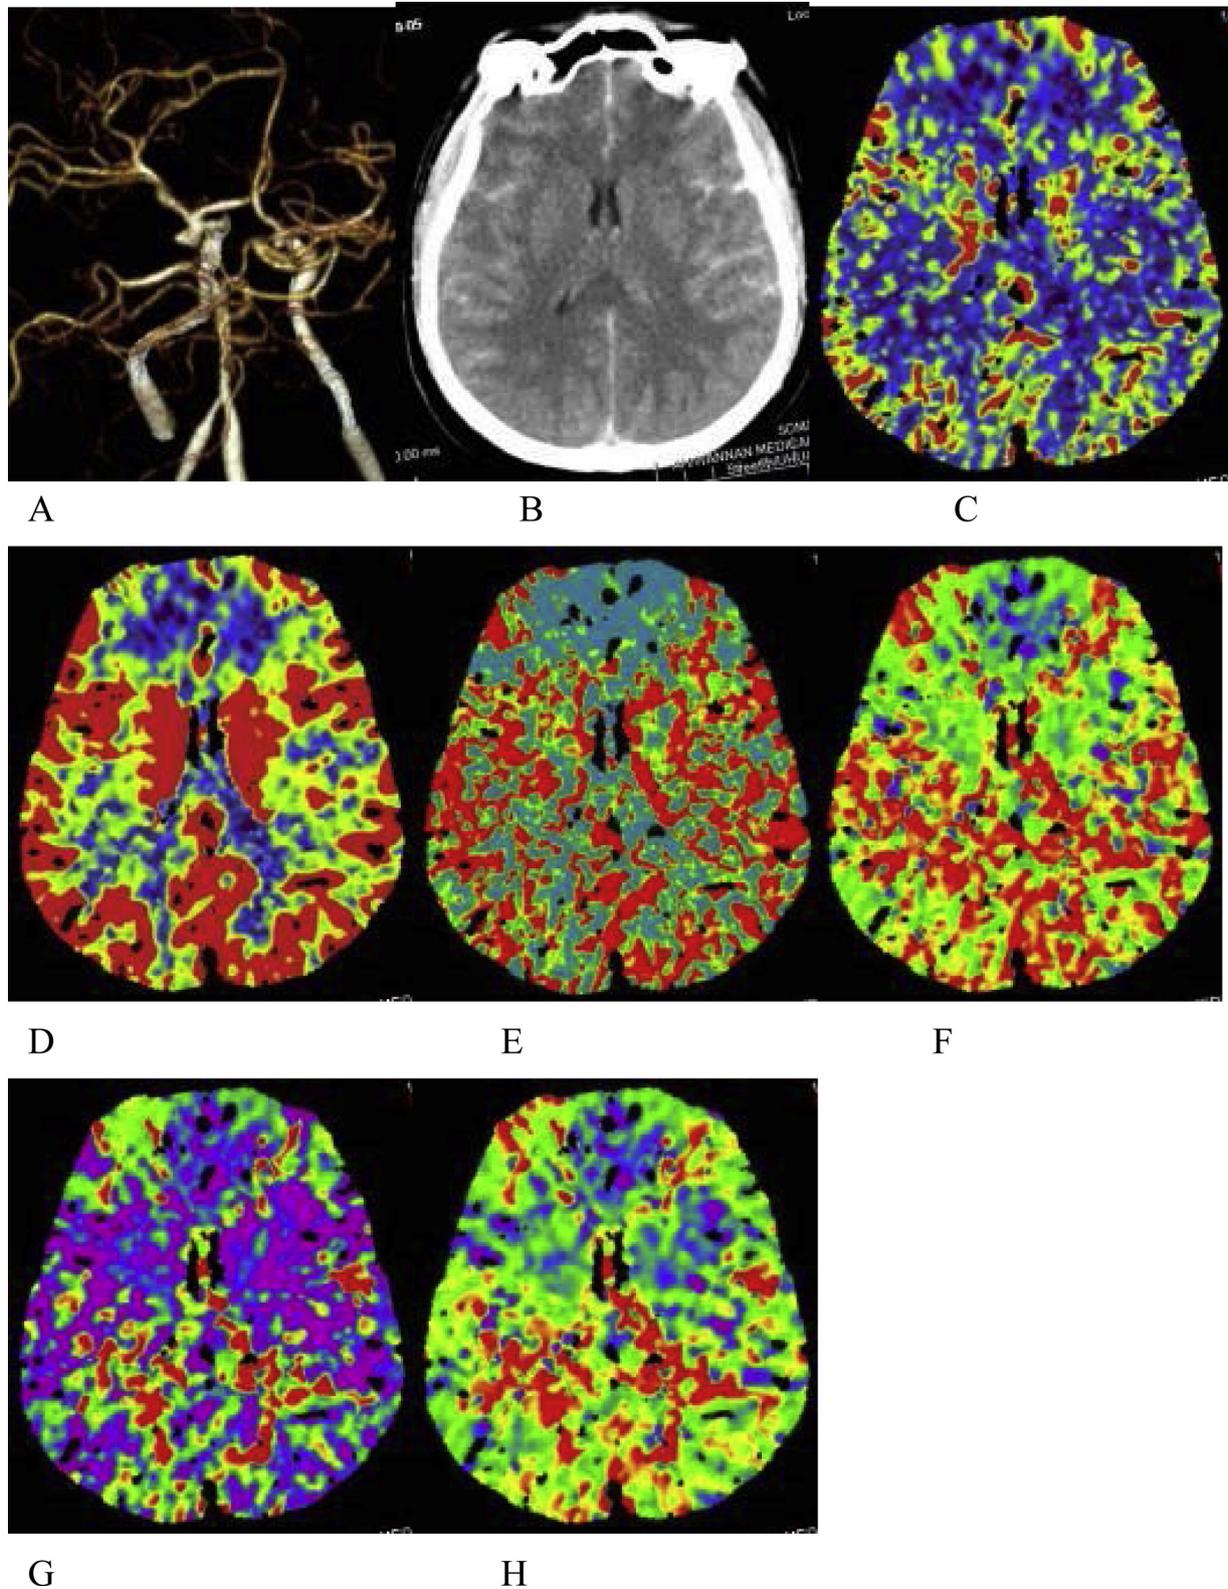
A 43-year-old male patient with ruptured left posterior communicating aneurysm on admission who died 11 days later. CTA (A) showed left posterior communicating aneurysm. The Fisher score was 3 on NCCT (B). Color-coded maps of CTP parameters (C–H) revealed whole-brain perfusion abnormalities showing decreased CBF (C) and CBV (D), and significantly prolonged MTT (E), TTD (F), TTS (G), and TMax (H).
